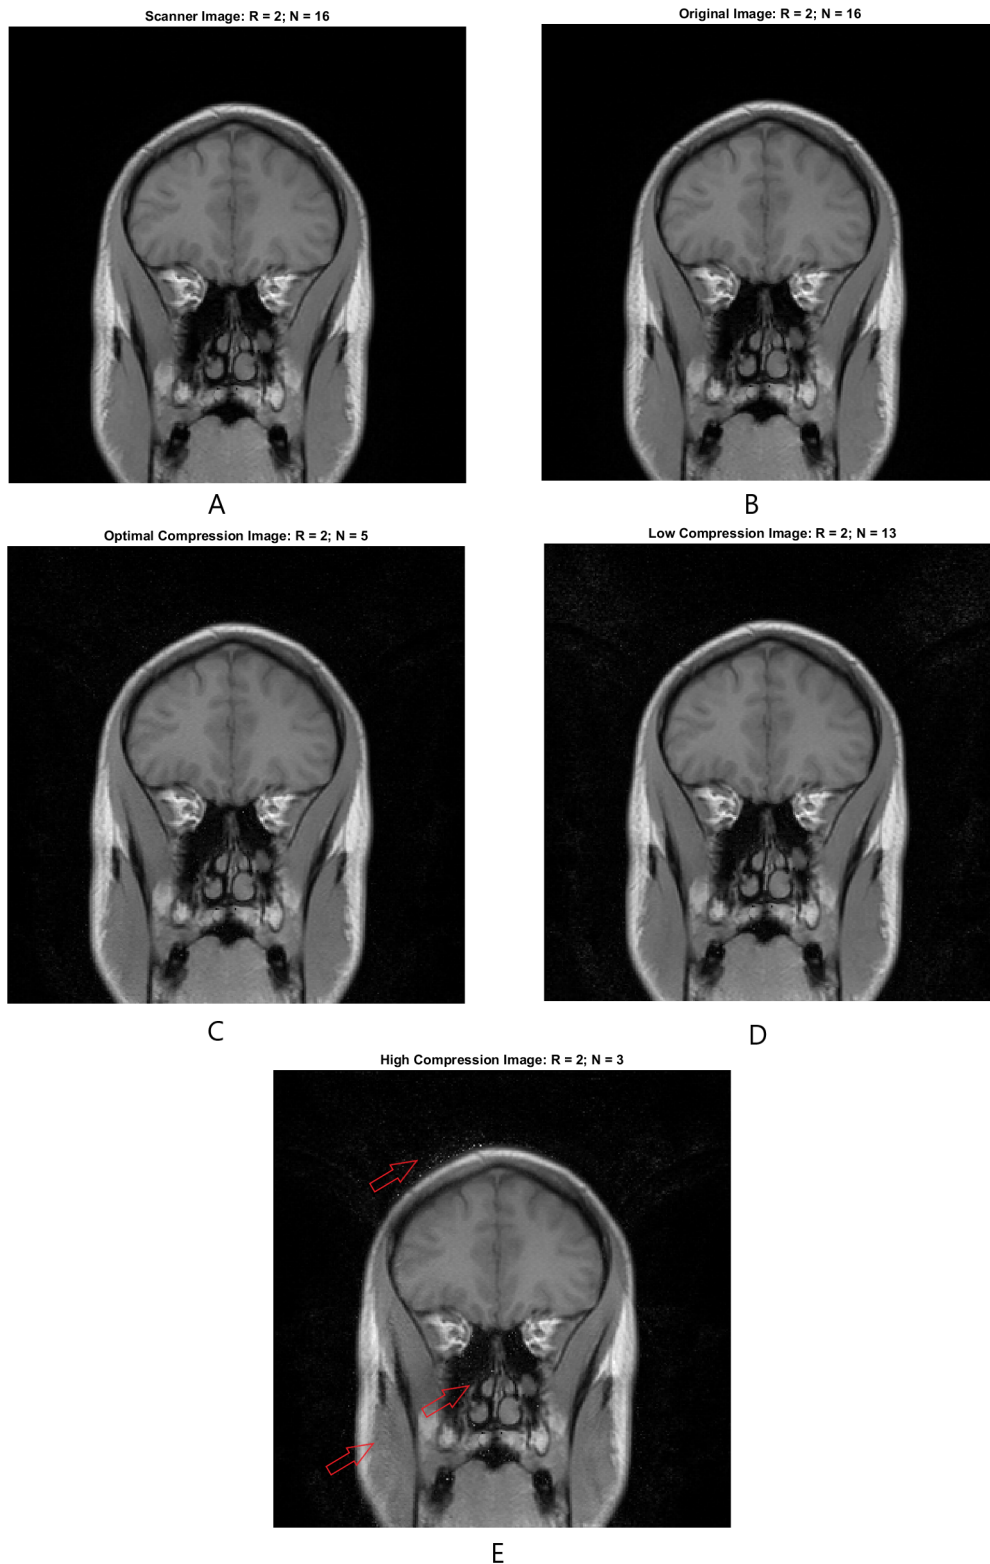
T1-weighted anatomical brain images on the coronal plane. Reference image reconstructed by Prisma scanner (A) is shown as well as offline reconstructed images without CC (B), with moderate CC (C), negligible CC (D) and considerable CC (E). Considerable CC enhances GRAPPA-generated overlapping artifacts, as designated with red arrows for better distinguishability. CC generates substantial artifacts around maxillary sinuses, more specifically at the border of the air-filled sinuses and the forming bone structure. Magnetic susceptibility changes significantly at the boundaries which is favorable for enhanced artifact occurrence.
